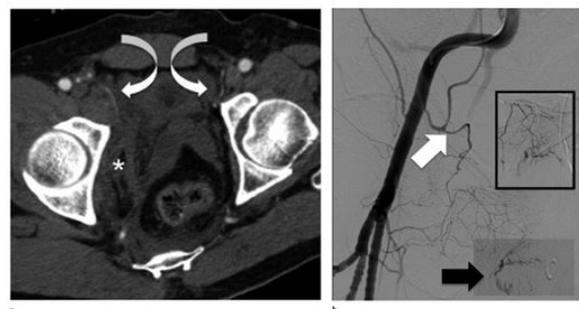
Evaluation of corona Mortis using angiography [7]. In conclusion, as highlighted in this brief article, there is a potential role for early CT imaging of the pelvis to evaluate additional PPRI. In pelvic trauma and haemodynamic compromise, haemorrhage from corona Mortis should be considered and evaluated with angiography techniques. With the increased availability of CT imaging, this mode of investigation is likely to become the initial preferred mode of imaging.
